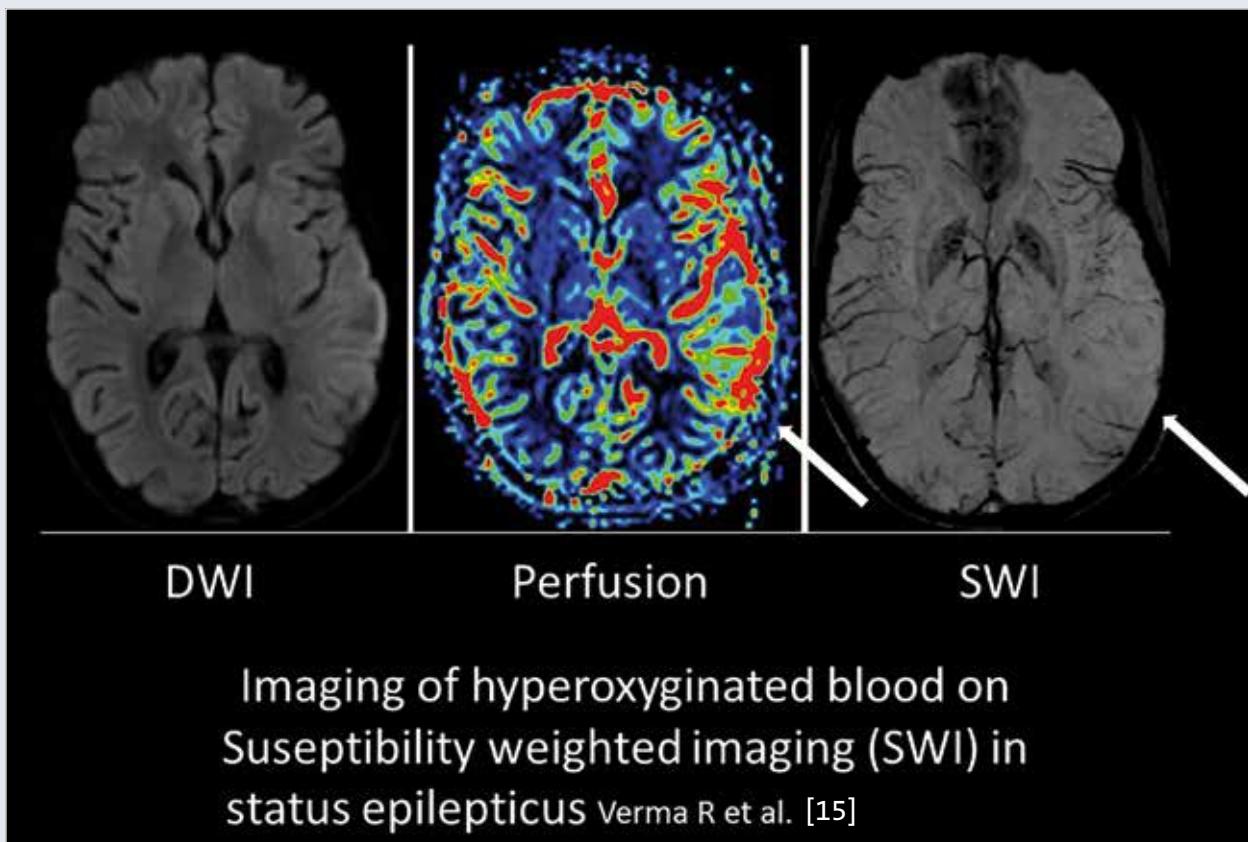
SWI showing on the right side disappearance of hypointensive signal in cortical veins in the region of ongoing hyperperfusion (middle image) during non-convulsive status epilepticus. The diffusion weighted imaging (DWI) (left image) detects a diffusion restriction within the symptomatogenic zone as defined by the perfusion imaging of the current status epilepticus.
